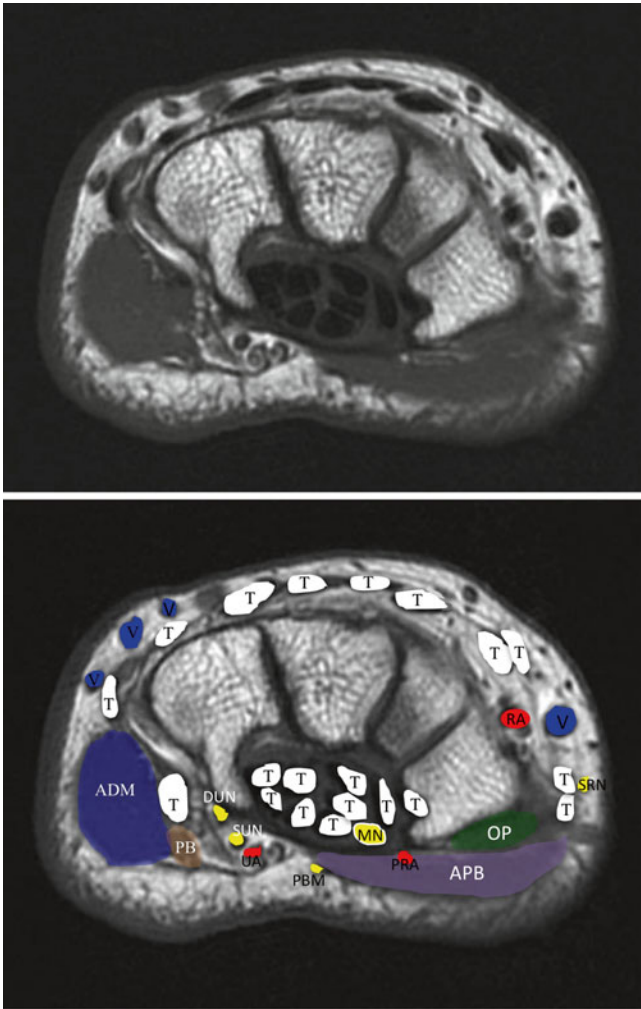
Wrist axial MRI. *A* artery, *APB* abductor pollicis brevis, *DUN* deep branch of the ulnar nerve, *MN* median nerve, *OP* opponens pollicis, *PB* palmaris brevis, *PMN* palmar branch of the median nerve, *PRA* palmar radial artery, *RA* radial artery, *SRN* superficial branch of the radial nerve, *SUN* superficial branch of the ulnar nerve, *T* tendon, *UA* ulnar artery, *V* vein (Image courtesy of Andrea Trescot, MD)
